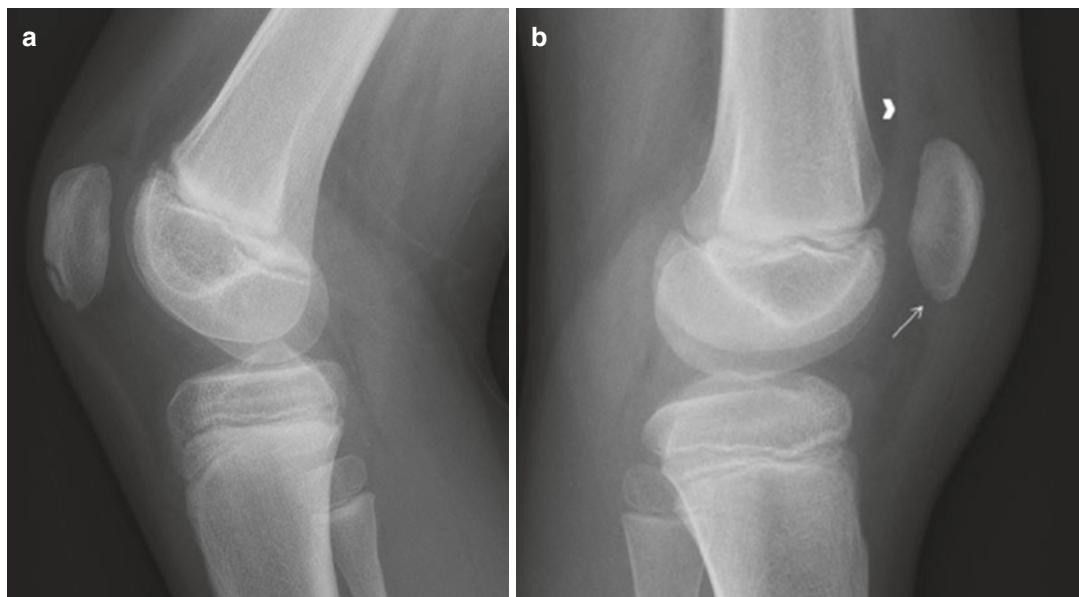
Lateral radiographs of the knee. (a) Bony fragment at the anterior inferior pole of the patella, which is well defined with sclerotic margins. This represents a normal secondary ossification center, which is often seen
